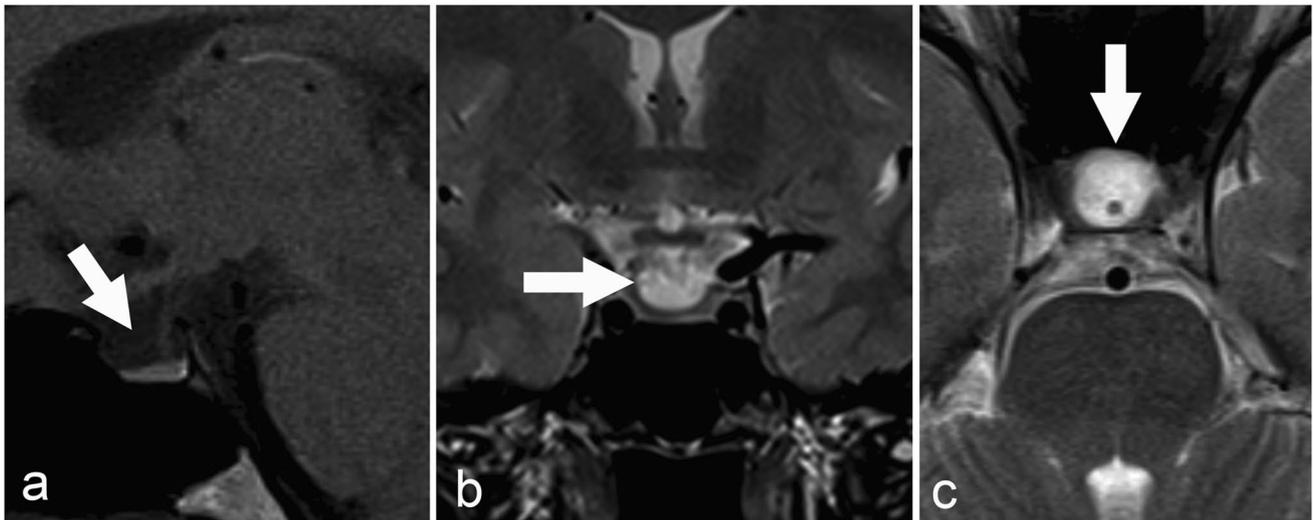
Non-contrast MRI (panels a–c) of the pituitary gland with sagittal (a) and axial (c) T2-weighted as well as coronal T1-weighted dedicated 3-mm thin-sections from case 1, demonstrating thin rim of pituitary tissue along the anterior and inferior aspects of the enlarged
